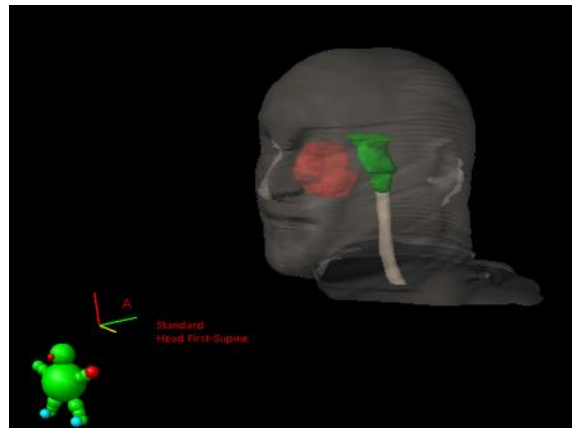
A CT image imported in Eclipse TPS and examples of contoured structures. Planning target volume is indicated as red, brainstem as green and spinal cord as white.
